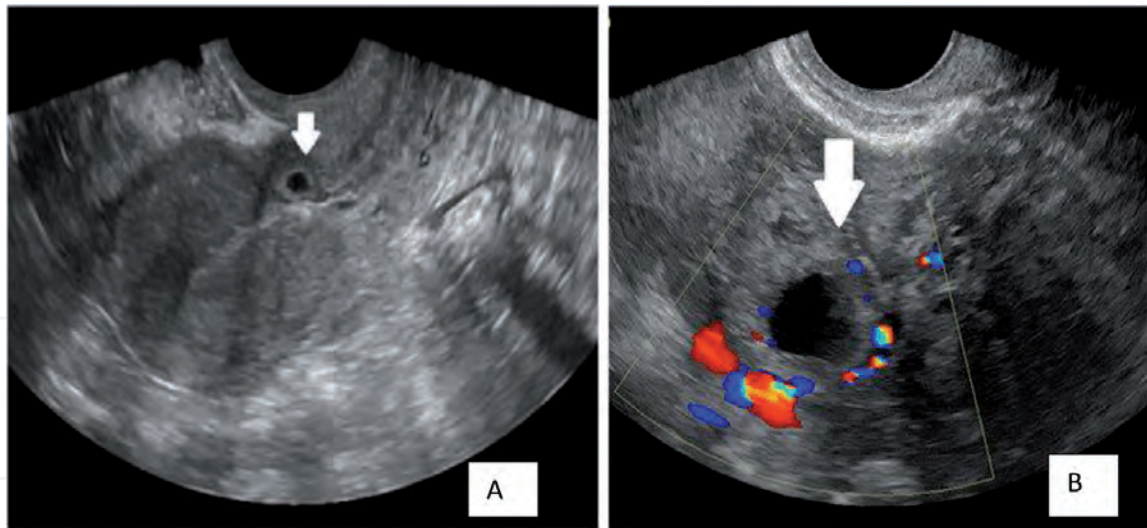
Cesarean section scar ectopic pregnancy. Transvaginal ultrasound with 2-D and power Doppler showing: (1) normal uterine cavity and endometrium, (2) gestational sac in the cesarean section scar anteriorly, and (3) the vasculature around the gestational sac (white arrows) [25]. (A) shows cesarean ectopic pregnancy on a gray-scale ultrasound, and (B) shows the same pregnancy on color Doppler showing ring of fire of vessels around the gestational sac.
